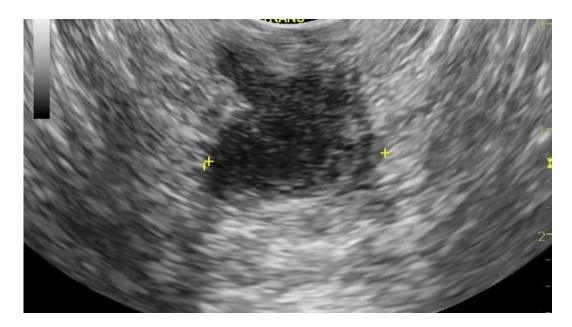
Anal abscess by transrectal ultrasound Patel M, Perianal abscess. Case study, Radiopaedia.org (Accessed on 15 Sep 2024) https://doi.org/10.53347/rID-21116
